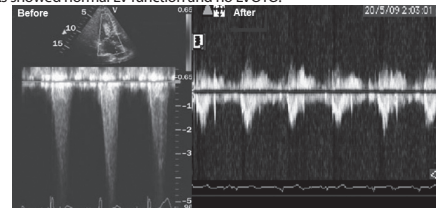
Echocardiography disclosed a peak gradient of 140 mmHg at LVOT. LVOT gradient reduced to 20 mmHg on control echocardiography.
